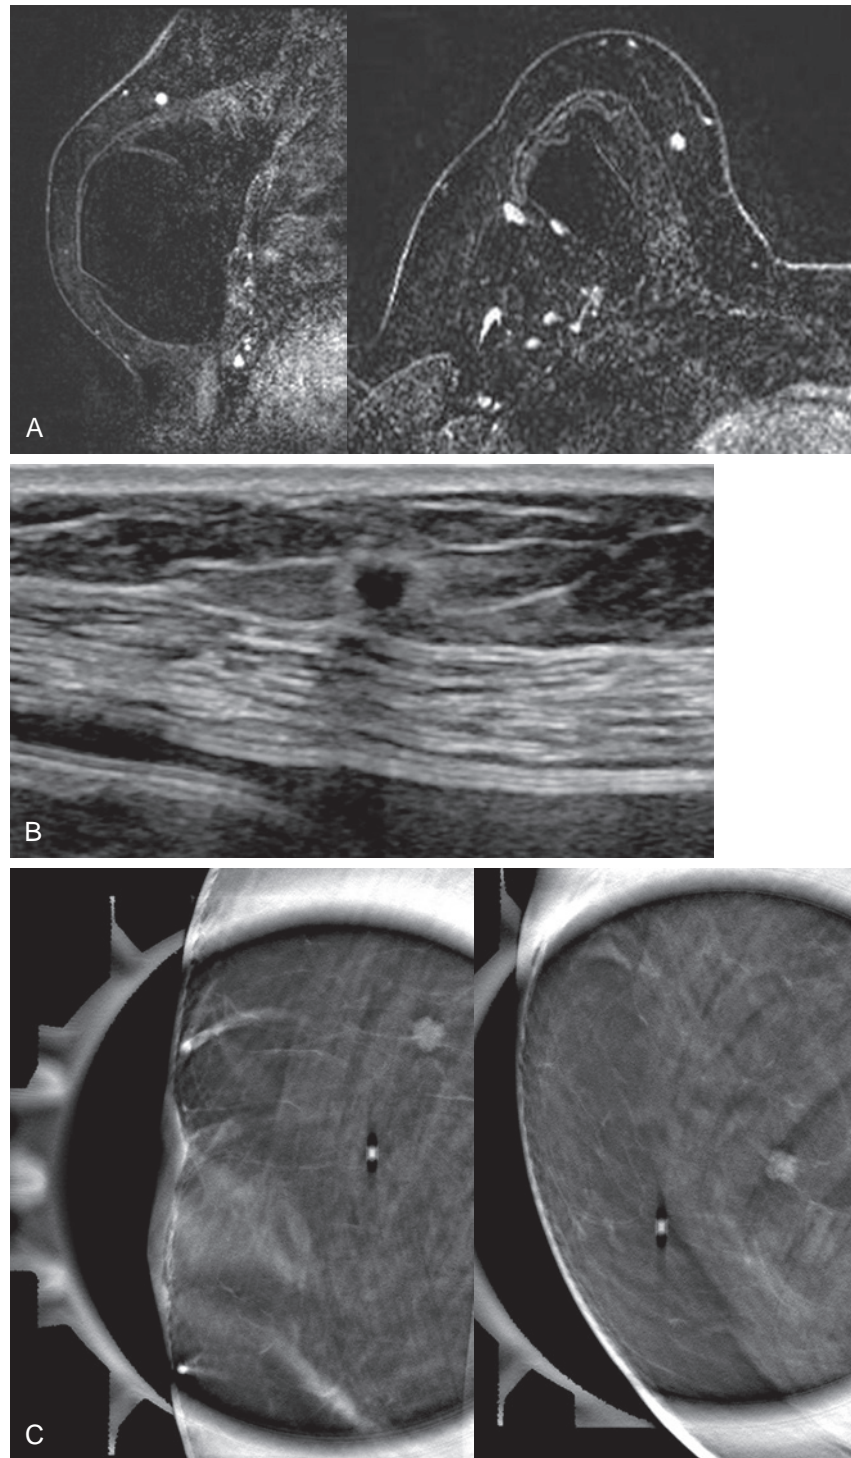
(A) Screening magnetic resonance imaging (MRI) in a 62-year-old woman with a known BRCA-2 mutation and history of right breast cancer, status post-bilateral nipple sparing mastectomies with subpectoral implant reconstructions. T1-weighted sagittal and axial post-contrast subtraction images demonstrate a 6-mm enhancing, oval mass with a circumscribed margin in the upper-inner quadrant of the reconstructed right breast, new since the prior MRI 3 years ago. (B) Targeted ultrasound reveals a round hypoechoic mass with microlobulated margins and a hyperechoic rim. (C) A BB was placed on the skin overlying the abnormality, and spot tomosynthesis compression views reveal a lobulated mass with spiculated margins corresponding to the MRI and ultrasound findings. Pathology revealed a moderately differentiated infiltrating ductal carcinoma, ER+/PR+/Her-.
